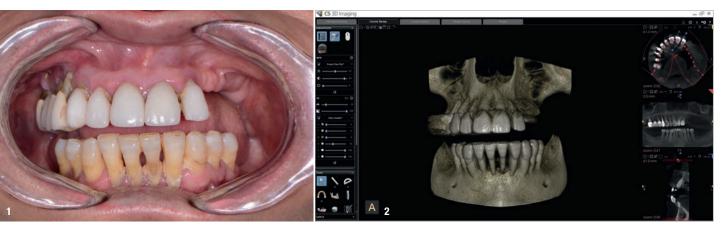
Pre-op retracted frontal view. Fig. 2: CBCT scan using the CS 8100 3D (Carestream Dental).
